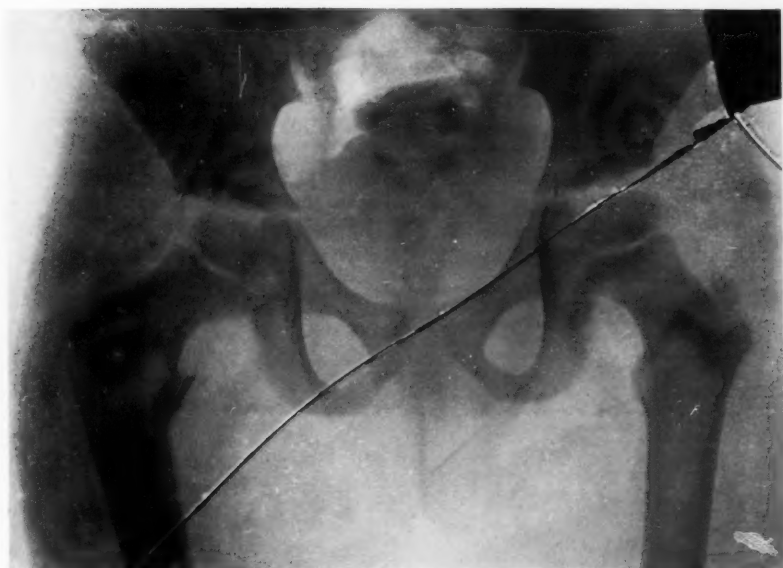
Case XIII. X-ray of same patient taken three days later, showing fracture at site of lesion due to fall.
